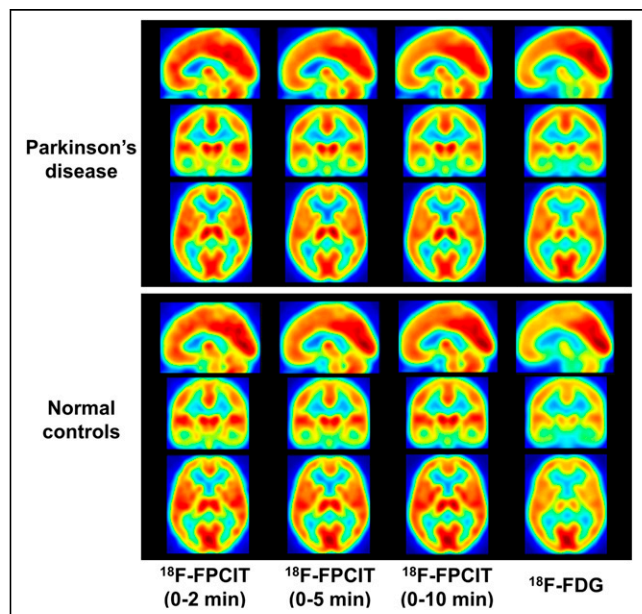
Mean images of PD patients and HCs from early-phase ^{18}F -FPCIT and ^{18}F -FDG PET after spatial normalization into a standard brain space. There was high similarity between mean ^{18}F -FPCIT images over first 2, 5, and 10 min after injection and corresponding ^{18}F -FDG images.
